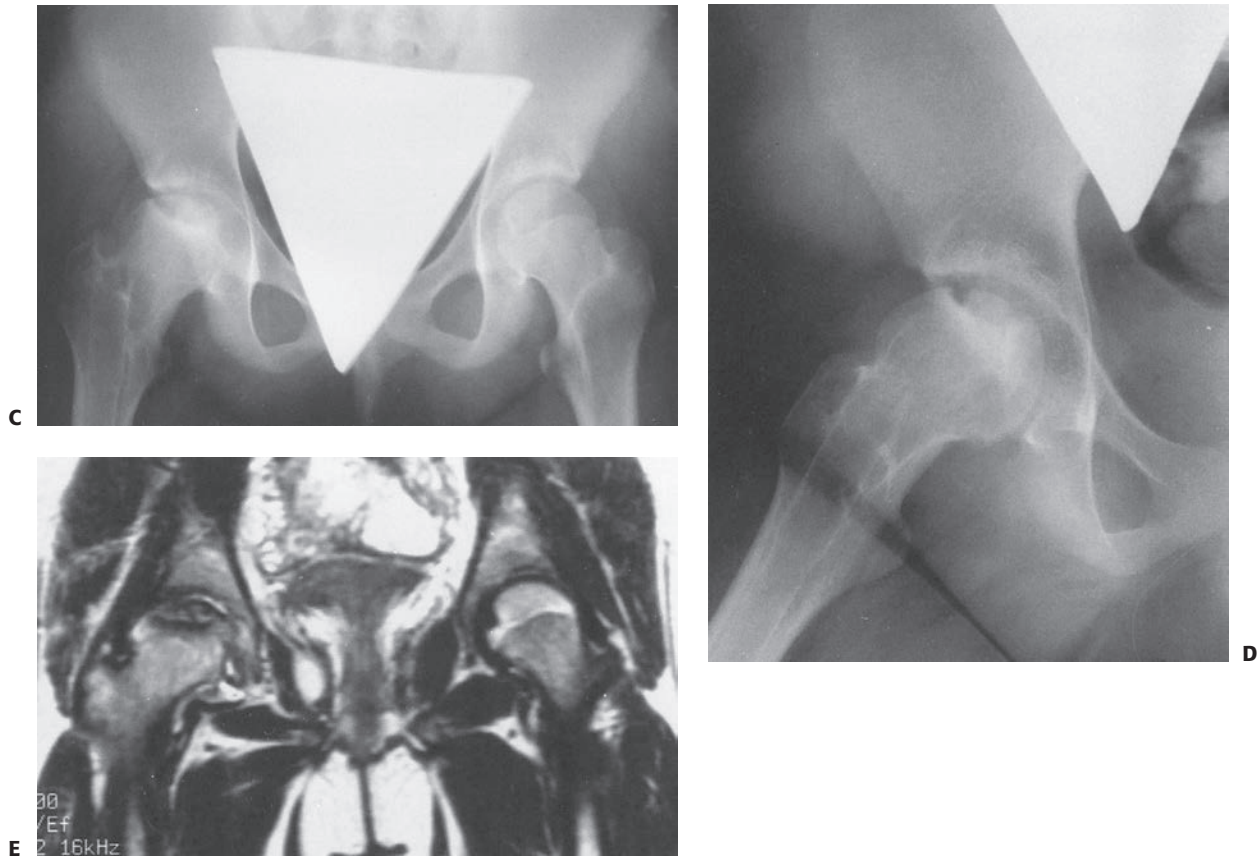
(continued) C: Eight months after injury, fracture is healed; note early signs of osteonecrosis of right femoral head. D: Fifteen months after injury, segmental osteonecrosis of the femoral head is evident on x-rays. E: Magnetic resonance image shows extent of osteonecrosis of right femoral head. (D reprinted from Beaty JH, Austin SM, Warner WC, et al. Interlocking intramedullary nailing of femoral-shaft fractures in adolescents: Preliminary results and complications. *J Pediatr Orthop.* 1994;14:178–183, with permission.)
